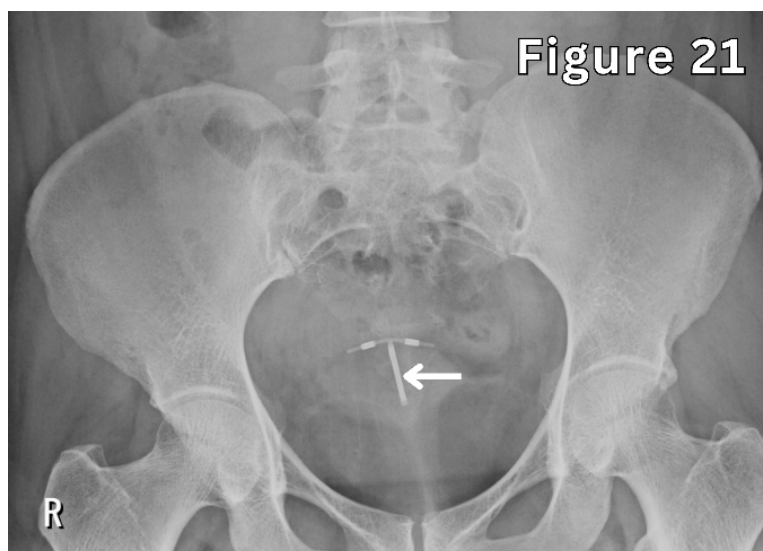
Pelvic X-ray showing an intrauterine contraceptive device (copper T-loop) in normal position.
